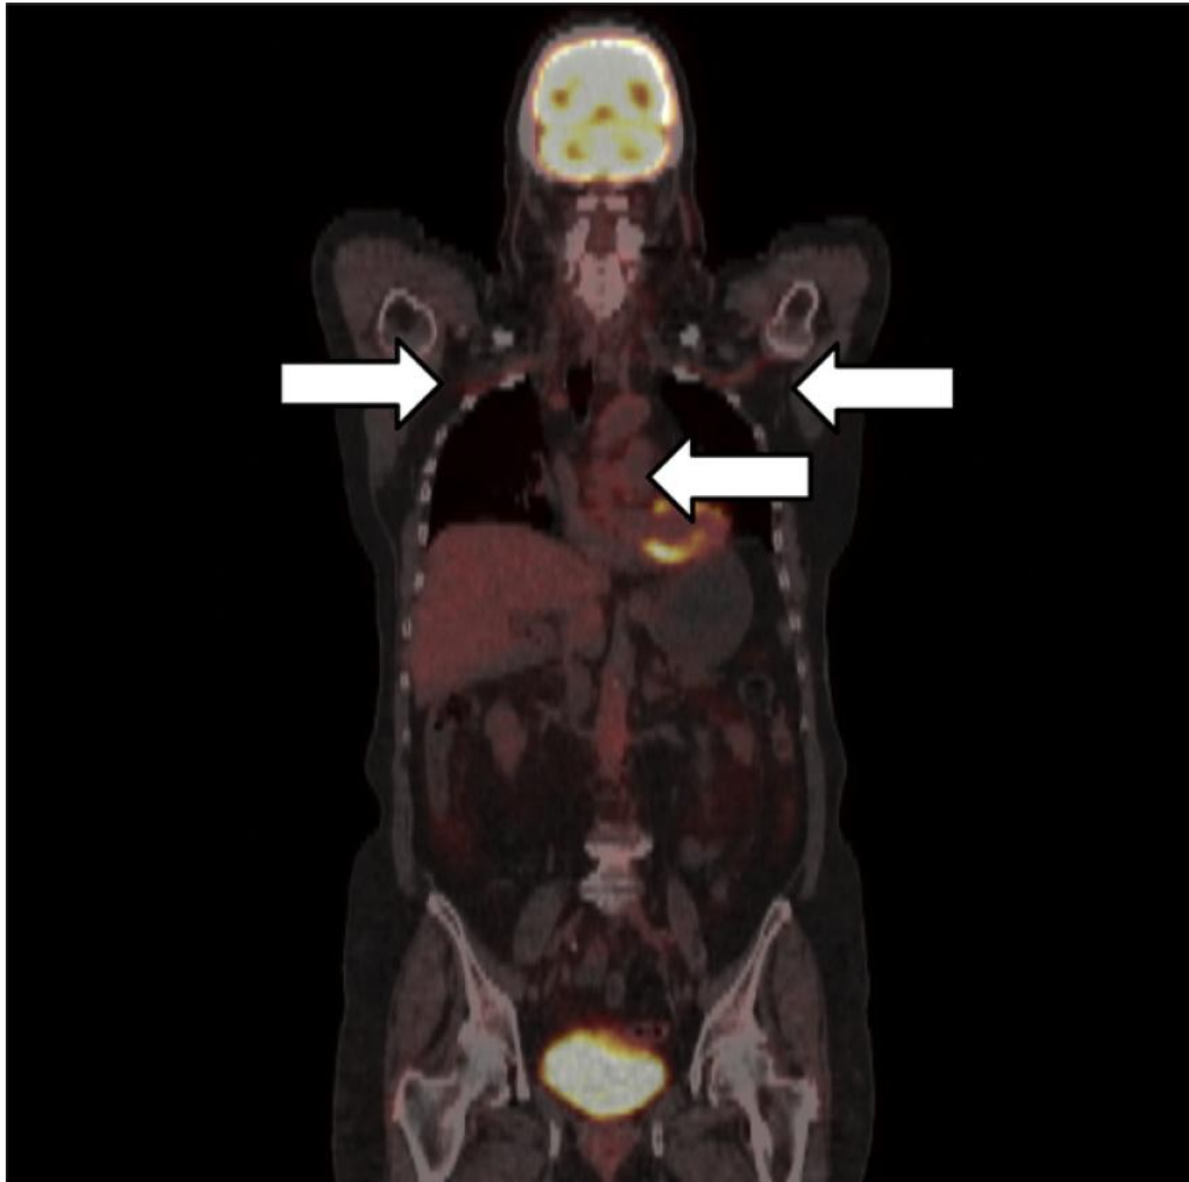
Fusion image of PET-CT showing vasculitis of the ascending aorta, the subclavian and axillary arteries in large-vessel GCA. Courtesy Prof. Dr. Stefan Dresel, Dept. of Nuclear Medicine, Helios Klinikum Berlin-Buch, Germany.
